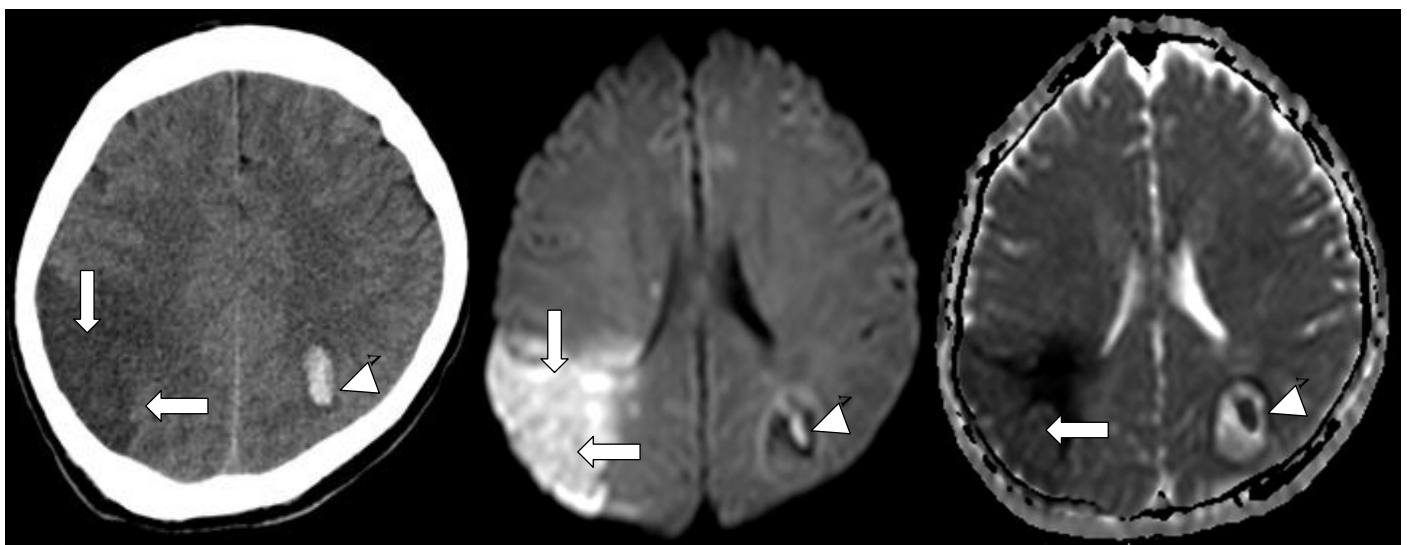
Neuroimaging of a 29 year-old female with dengue infection showing wedge-shaped acute infarct at the right parietal lobe (arrows) with a focal hemorrhage at the left parietal lobe (arrowheads). A, unenhanced CT scan. B, DWI. C, ADC. Magnetic resonance angiography (MRA) was unremarkable.
